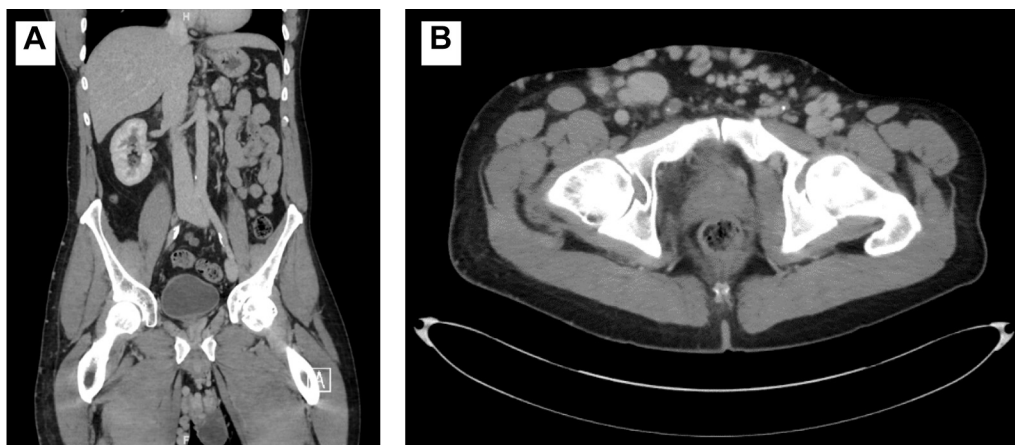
Computed tomography scan. A, Absence of right iliac vein with blind ending pouch at the right inferior border of the inferior vena cava. B, Abdominal wall varicosities.
